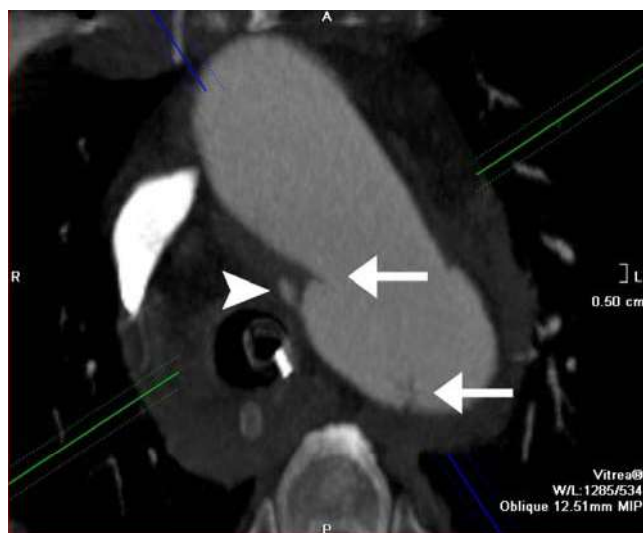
Preoperative CTA of a contained aortic rupture. Double oblique paracoronary maximum-intensity projection through the aortic arch showing traumatic transection (arrows) and contained rupture (arrowhead) of the distal aortic arch
